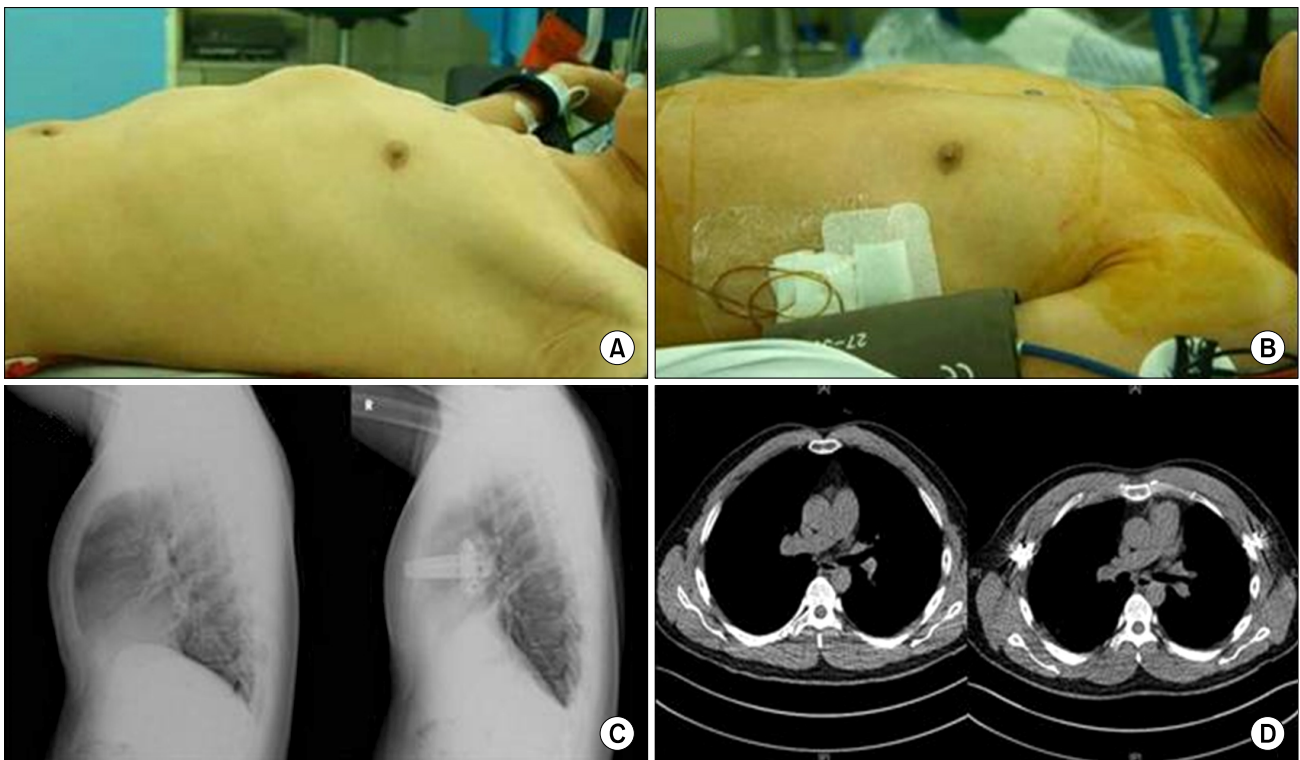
Preoperative and postoperative findings. (A) A photograph of the anterior chest wall before surgery. (B) A photograph of the anterior chest after bar insertion. (C, D) Imaging shows improvement of the anterior protrusion of the chest wall after surgery. (C) Postoperative chest radiograph, lateral view. (D) Postoperative computed tomography.
